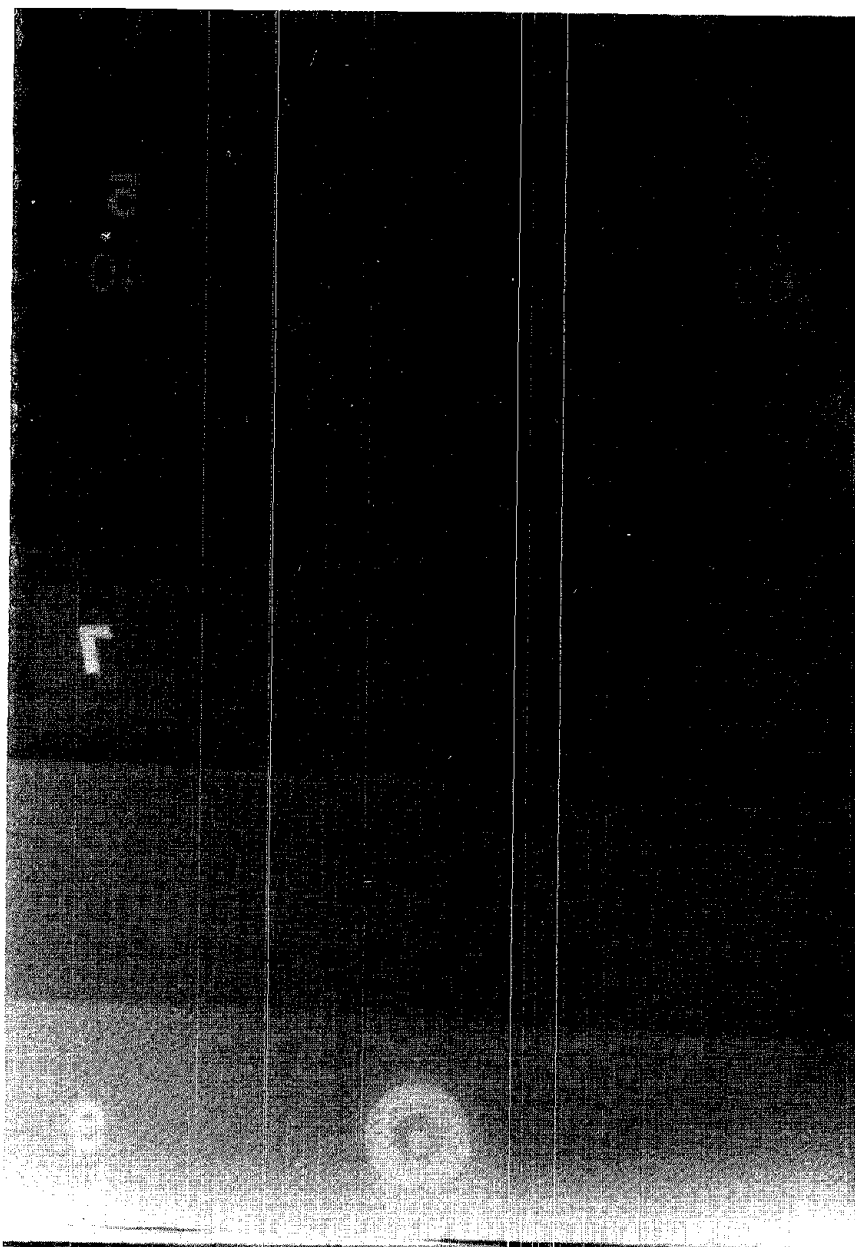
Radiograph chest test object where centering is good.
